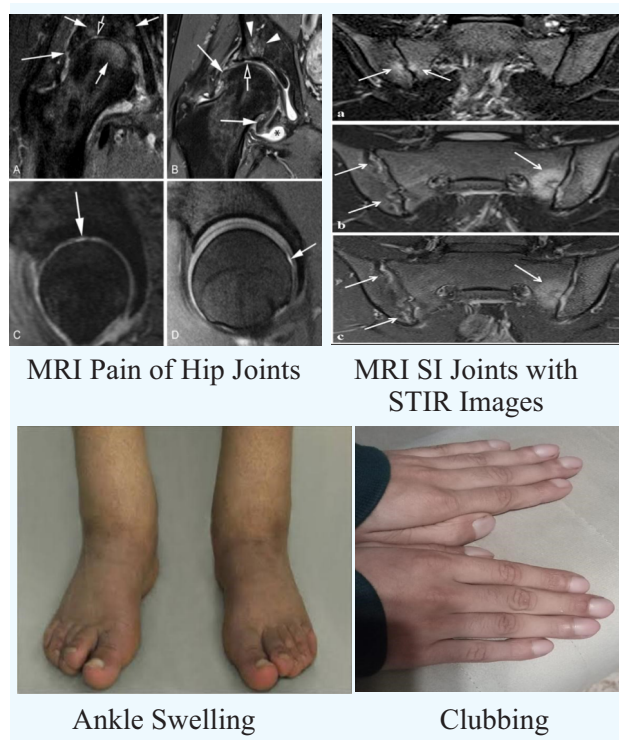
MRI and Patient presentation
